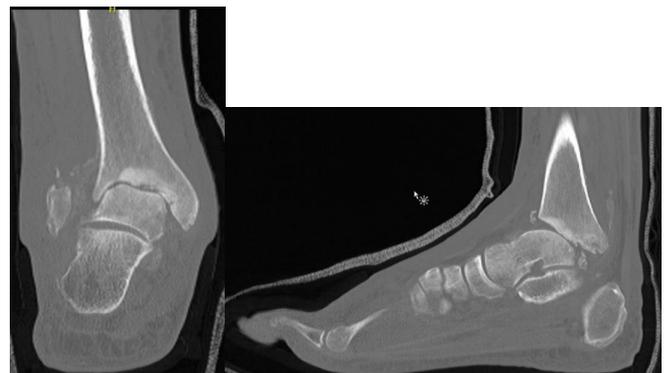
CT of right ankle.
